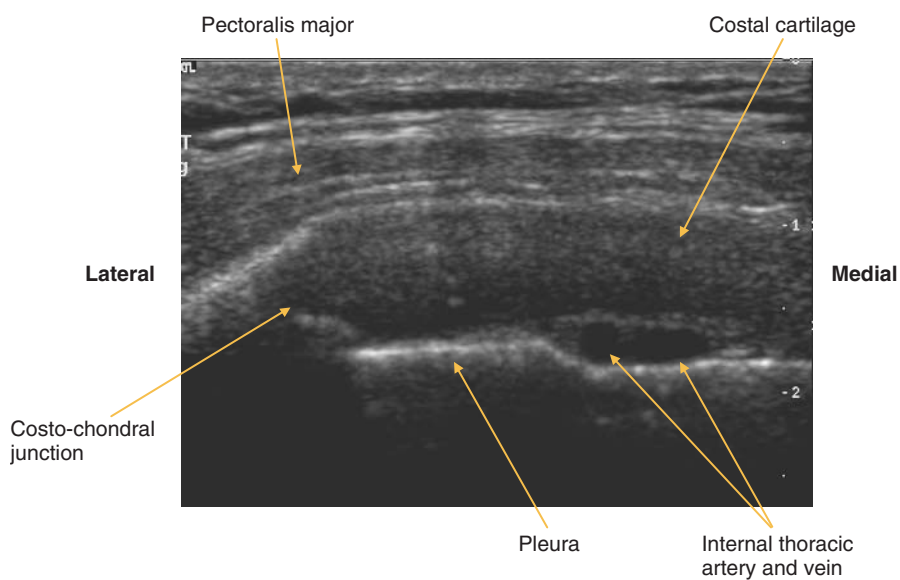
LS, chest wall parasternal
